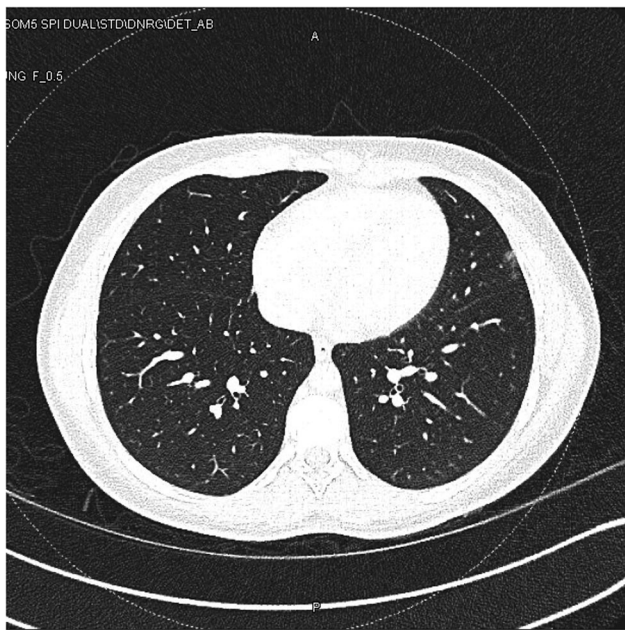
Case 8, chest CT: nodular tree-in-bud and ground-glass opacities, mostly in the lingula. CT, computed tomography
